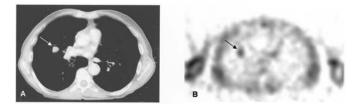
A 78-year-old male patient with a 12-mm single lung metastasis from colon carcinoma in the medium lobe of the right lung which appeared as an SPN at CT (A, arrow). <sup>99m</sup>Tc-tetrofosmin SPECT was true positive showing a focal area of increased uptake corresponding to the metastasis (B, arrow). T/N value was 2.1.
